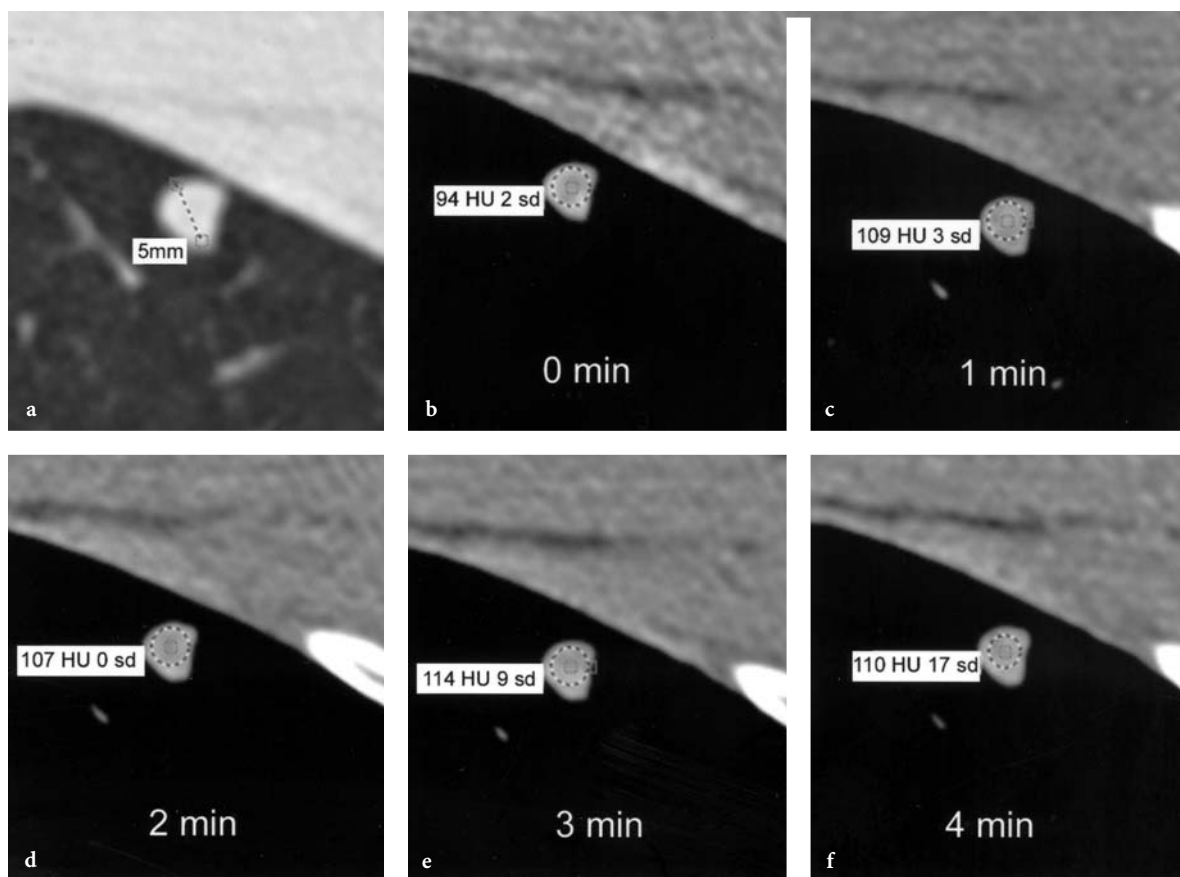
Nodule enhancement. a 3 mm target reconstruction through the lingual shows a well defined 5 mm nodule. b–f Representative 3 mm sections at the same level selected from repeated volume acquisitions through the nodule in a using a multidetector CT scanner first without and then following a bolus of intravenous contrast material. Note that this lesion enhances by 20 HU at 3 min. Although 15 HU has been reported as an accurate threshold differentiating benign from malignant lesions, in this case it was opted to follow this nodule conservatively. Subsequent scans have documented no growth over 2 years
